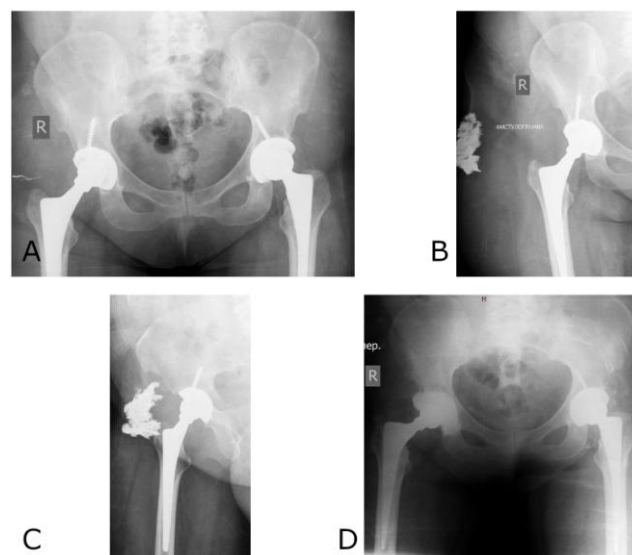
Radiographs of the pelvis: A) AP view before the revision operation; B, C) Fistulograph of the right hip joint before surgery; D) AP view after the intervention
